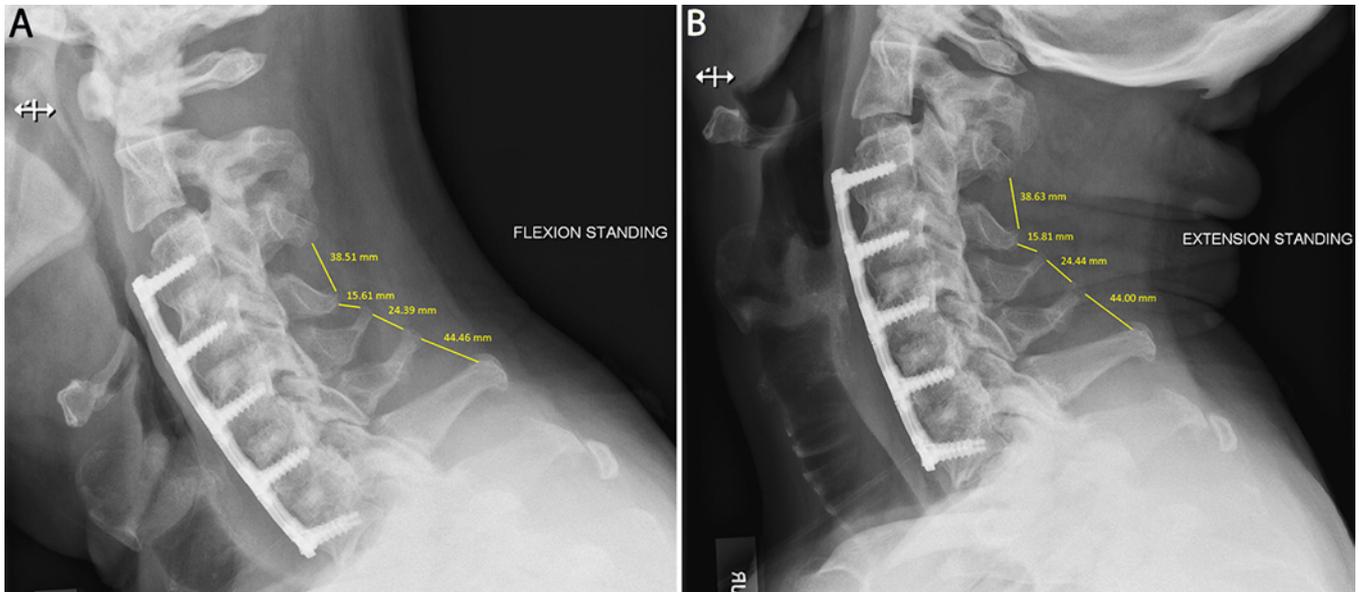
Representative radiographic outcomes and measurement technique after a 4-level ACDF operation. A: Lateral radiograph of the postoperative cervical spine during flexion. B: Lateral radiograph of the postoperative cervical spine during extension. Figure is available in color online only.
